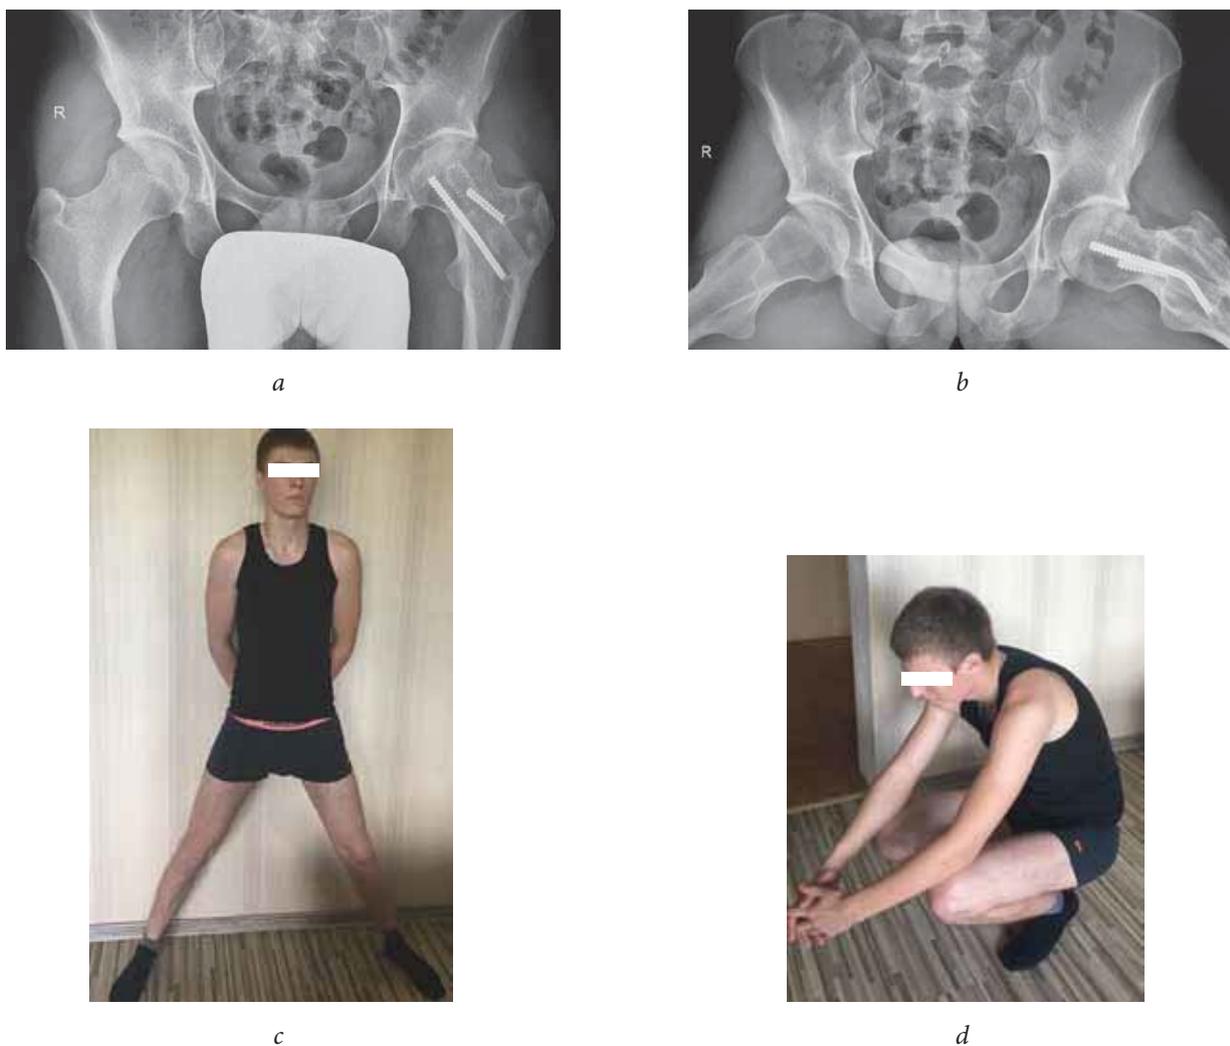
Patient M., 21 years old. Surgical treatment outcome after 7 years: *a* — radiograph of the hip joints in frontal projection: no signs of aseptic necrosis, secondary changes in the proximal part in the form of cam-impingement deformity; *b* — radiograph of the hip joints in the Lauenstein projection: no signs of aseptic necrosis, an increase in off set and angle α (cam-impingement); *c*, *d* — functional outcome 7 years after repeated surgical treatment: minimal restriction of abduction in the left hip joint, no pain syndrome
